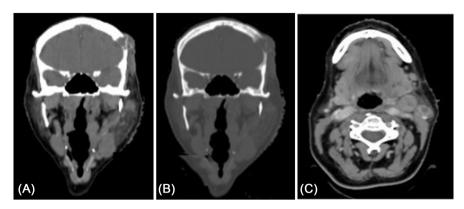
Coronal section of a cerebral CT scan, in parenchymal window (A) and bone window (B) showing a lesion of the left frontal scalp with lysis of the vault of the skull opposite. (C) Axial section of a cervical CT scan showing cervical adenopathies at the level of the left lymph node area III.
